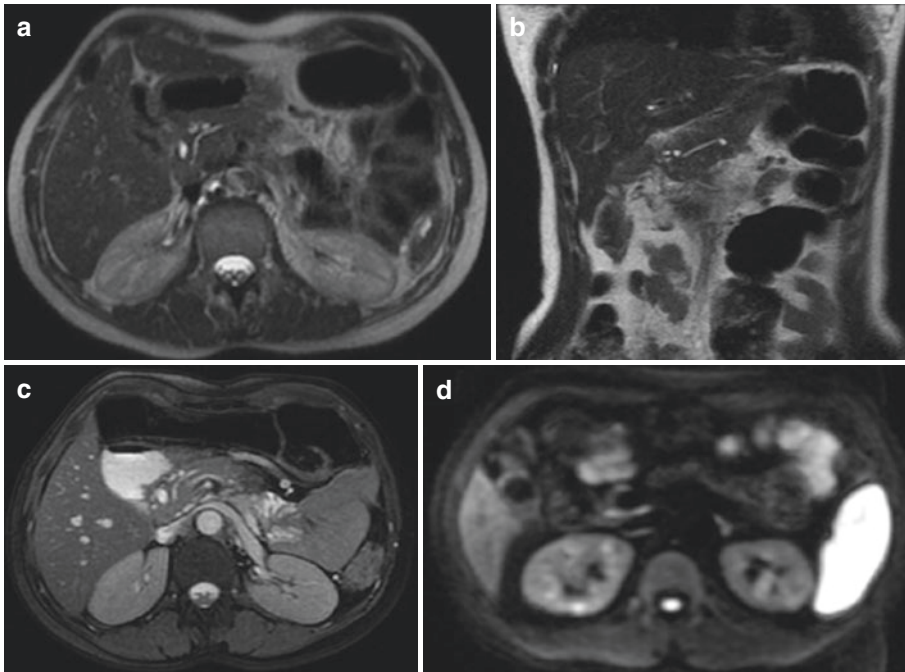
Standard MR imaging protocol. (a) Axial T2-weighted sequence. (b) Coronal T2-weighted sequence. (c) Axial balanced SSFP sequence. (d) Axial DW image
